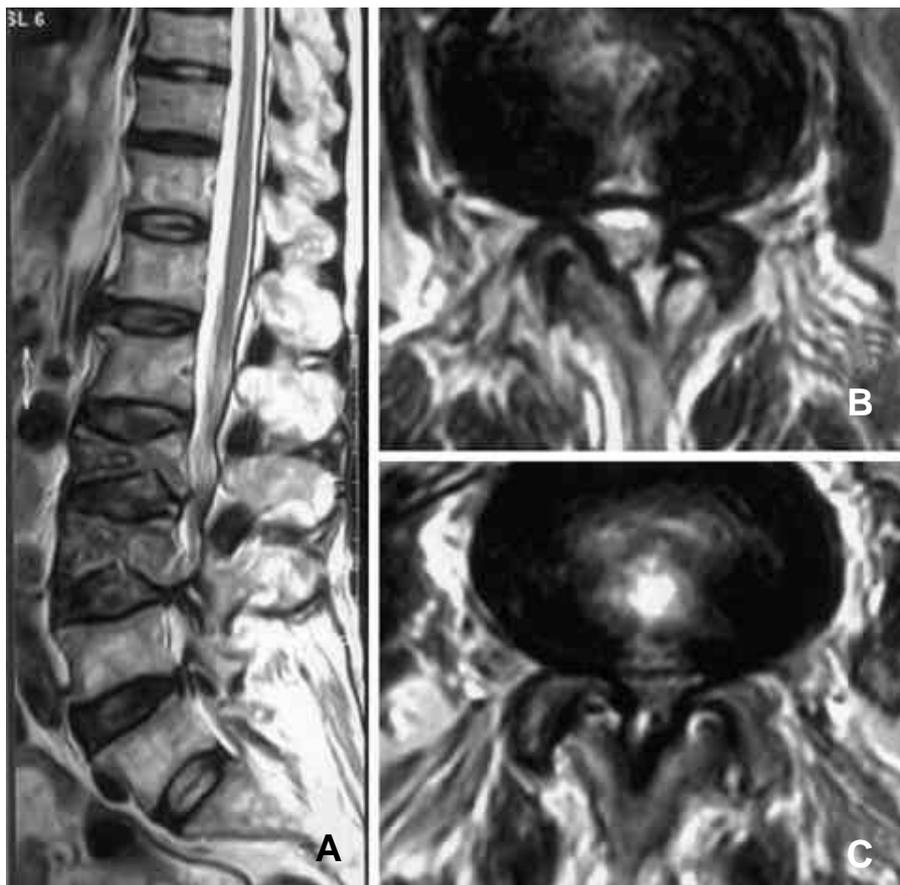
The sagittal T2-weighted MRI (A) shows biconcave fractures at L2 and L3 vertebrae. The spinal canal is narrowed at L2-3, L3-4, and L4.5 interlaminar spaces. The axial T2-weighted MRI of L2-3 (B) and L3-4 (C) show central and lateral recess stenosis.
